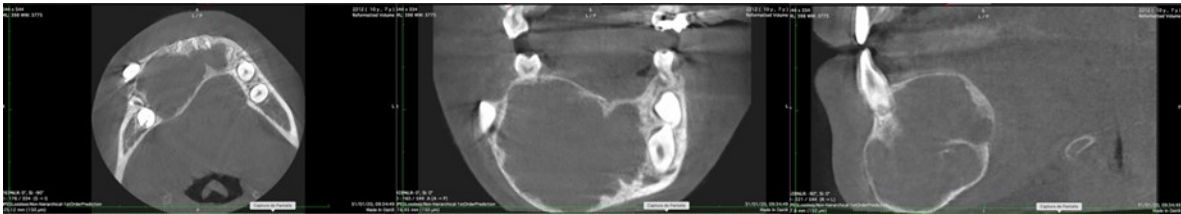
CBCT Axial, coronal and sagittal view showing expansion of cortical bone in the area of inferior incisors to premolars of the right side. Large multilocular regions are shown (arrows).
